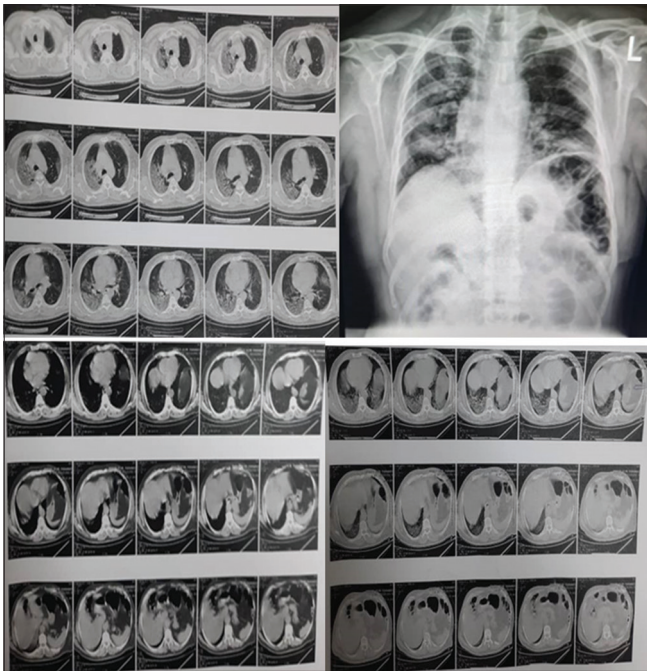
Transversal chest CT-scan and Chest X-Ray imaging from Patient seven
